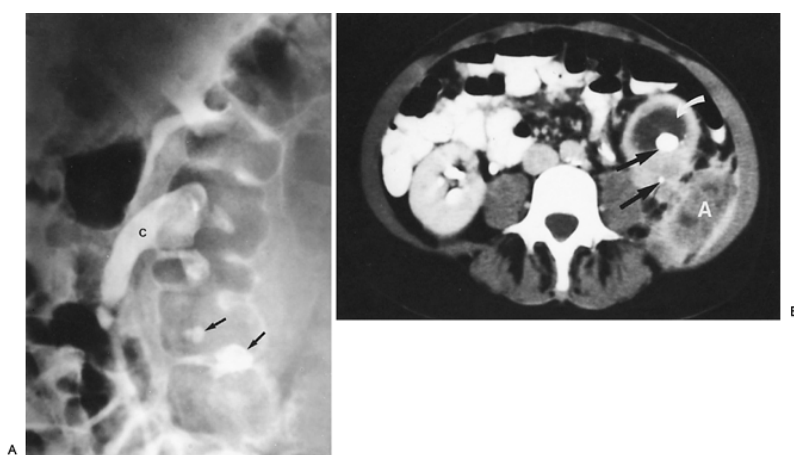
Xanthogranulomatous pyelonephritis. Excretory urogram. A: Ten-minute film shows lower-pole enlargement and nonfunction. Note a large pelvic calculus (*C*) and several smaller parenchymal calculi (*arrows*). The upper pole of the bifid collecting system functions normally. B: Enhanced computed tomography scan shows collecting system and parenchymal calculi (*arrows*) with lower pole pyonephrosis (*curved arrow*) and an irregular, predominantly low-density perinephric abscess (*A*) extending into the soft tissues of the flank.
